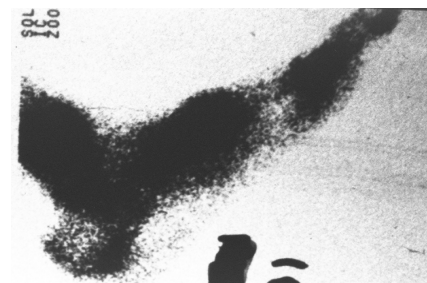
Falaka. Increased uptake in scintigraphy. 6 months after the beating of the feet.
